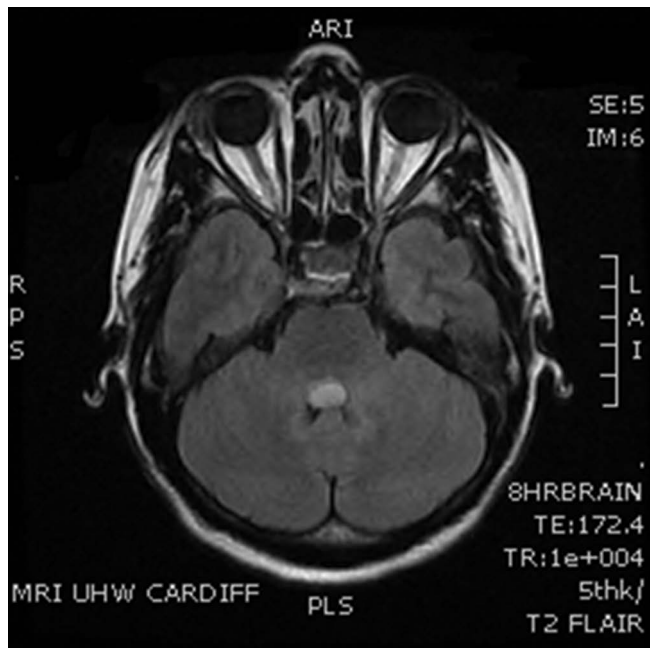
Axial T2 FLAIR magnetic resonance image showing fourth ventricular lesion
